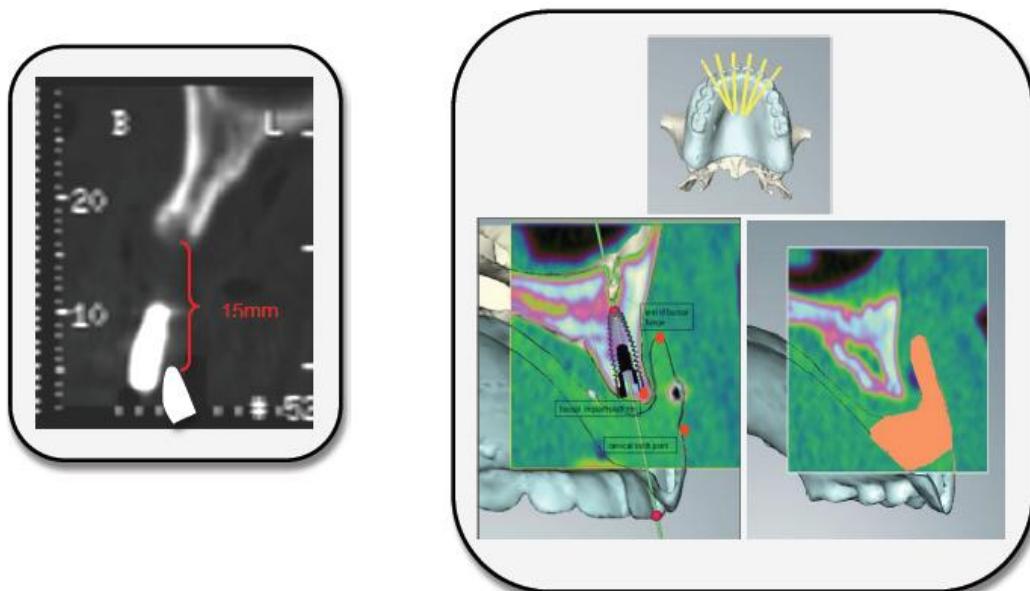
Decision making: fixed or removable prostheses. Treatment planning for the edentulous maxilla: Left: slice of CT-scan. It shows the jawbone and the position of the front teeth. A rough measure says, that an OD should be preferred, if the vertical distance between the incisal edge of the mandibular front teeth and the jawbone is around 15mm or more. Right: Virtual implant planning with specific software. Different measuring parameters are used for decision making whether fixed or OD is indicated. The right picture shows the amount of tissue that is currently replaced by the denture base material. It can be visualized in all 3 dimensions and in relation to the tooth position.
